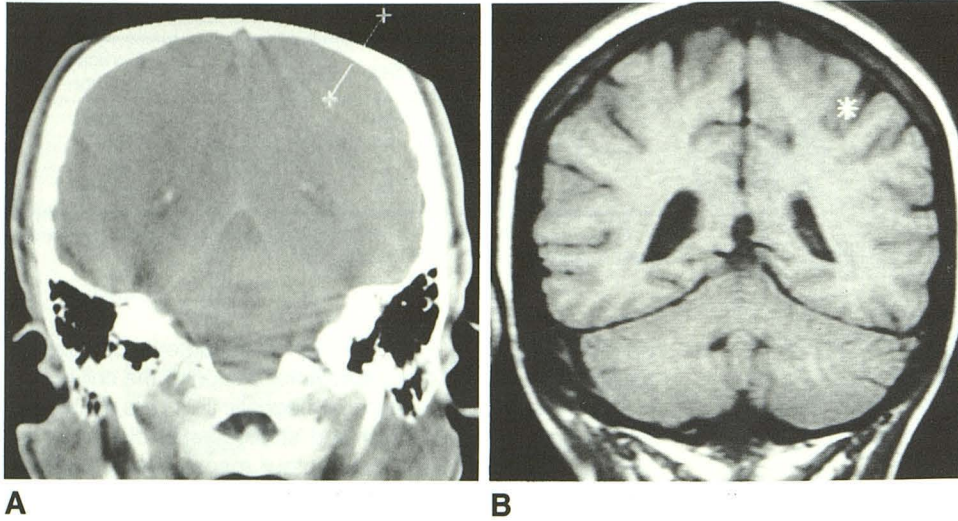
A, Coronal CT scan shows reference point determination of right index finger activity.
